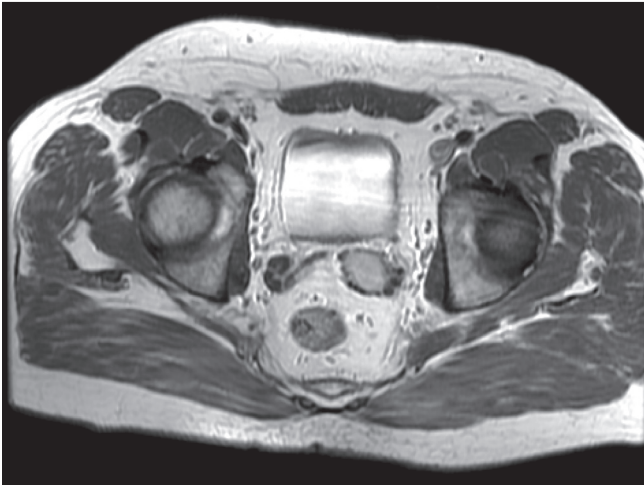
Magnetic resonance imaging cross section with low to intermediate intensity on T1-weighted images, showing a mass measuring 26 x 29 mm on the left seminal vesicle.
